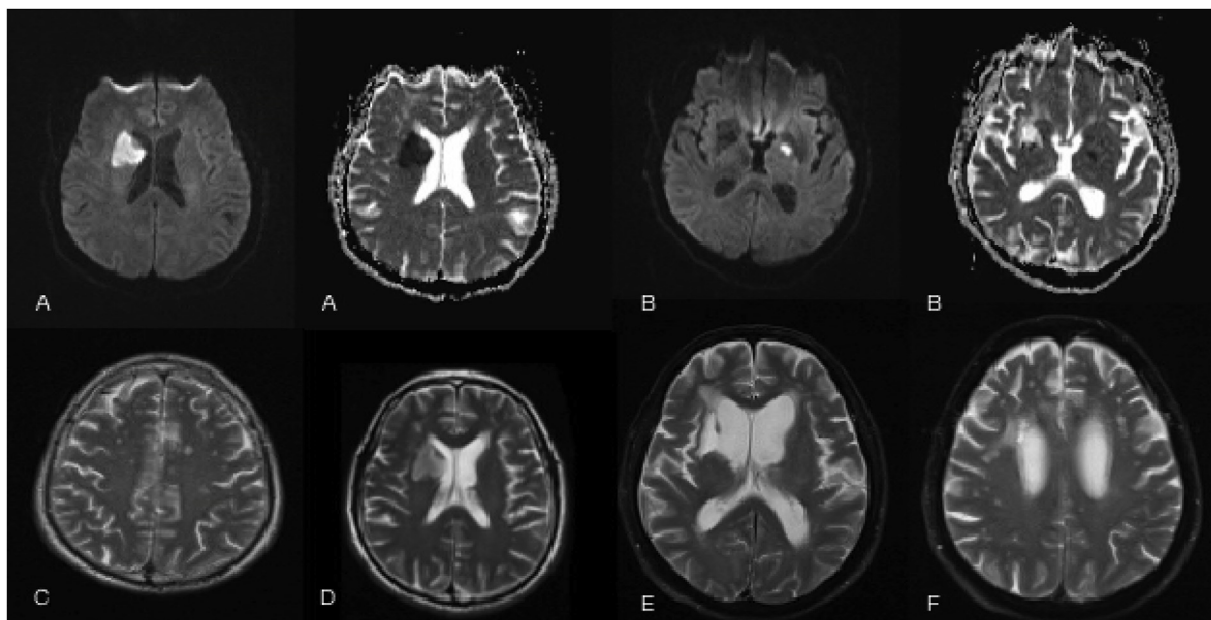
(A) Diffusion-weighted imaging and ADC mapping show acute ischemic lesions in the right caudate nucleus (B) Diffusion-weighted imaging and ADC mapping shows acute ischemic lesions in the internal capsule on the left side (C) T2-weighted cranial MR imaging shows bilateral centrum semiovale and periventricular subcortical white matter hyperintensities, cryptococcomas (D) T2-weighted cranial MR imaging shows the chronic ischemic gliotic area (E) T2-weighted cranial MR imaging shows cerebral atrophy and hydrocephalus in the following time of the treatment (F) chronic lesions in the post-treatment period.
